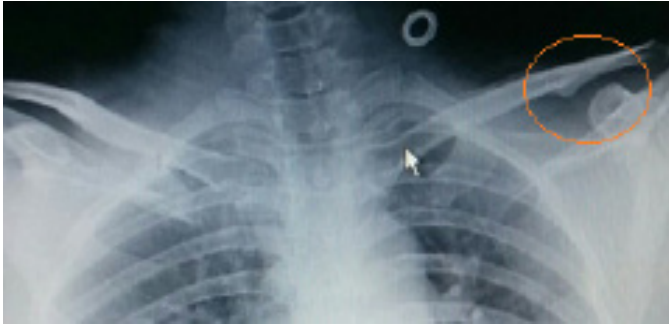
Radiograph of thoracic region (PA view) of 34 year old male showing unilateral (on left side) presence of CCJ (orange encircled area).
